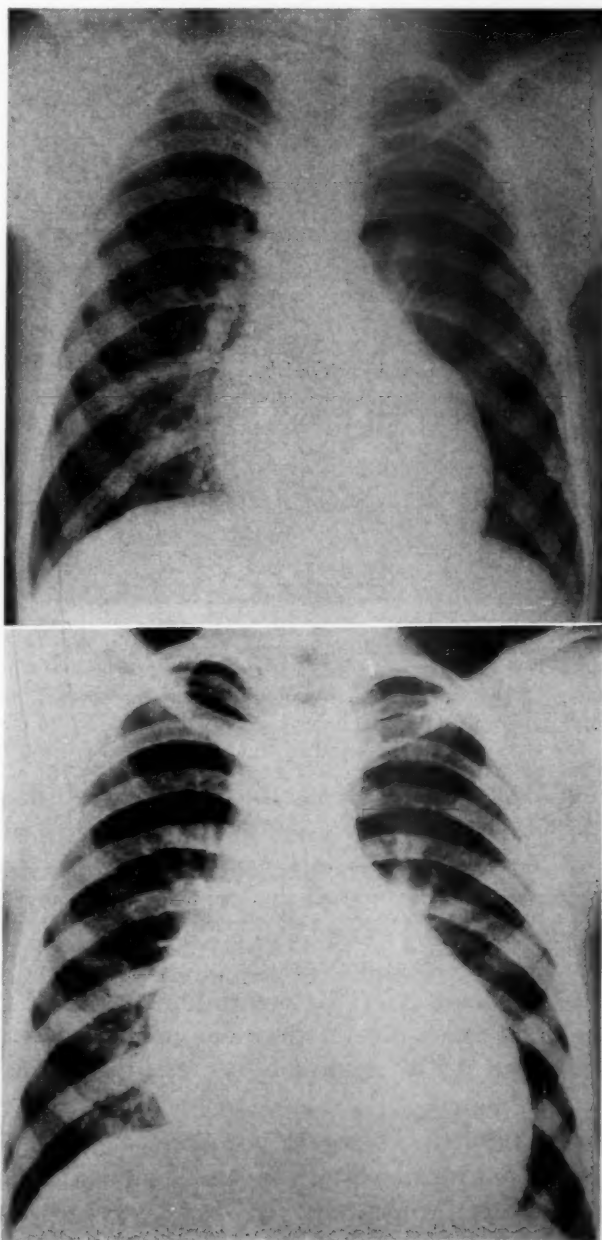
Roentgenograms of Patient M. D. A, Sept. 4, 1951. Note moderate cardiomegaly and normal pulmonary vasculature. Age 13 years. B, Jan. 6, 1954. Note increased cardiomegaly and pulmonary vascular congestion. Death occurred 3 months later at age 16 years.
